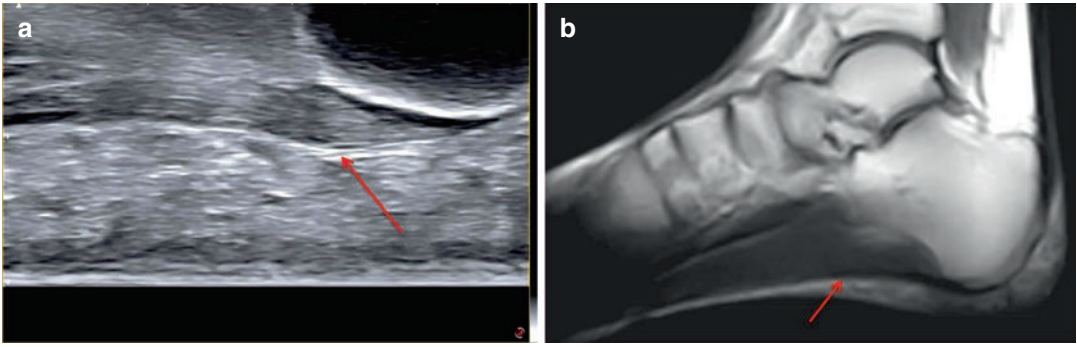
(a, b) Marked tissue stiffness due to plantar fasciitis depicted by dynamic upright US and MRI
